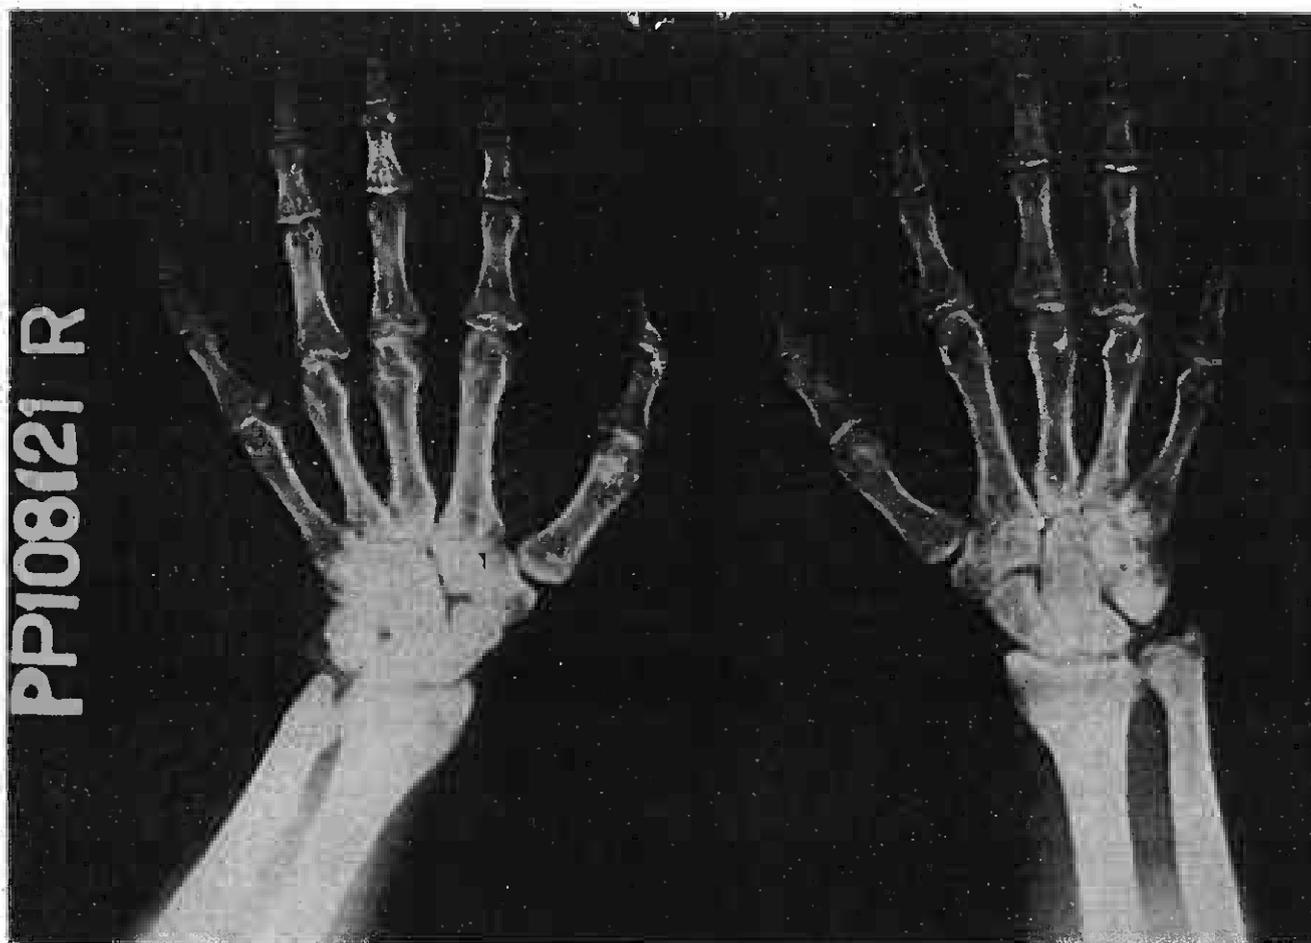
X-ray of the hands and distal forearms.
